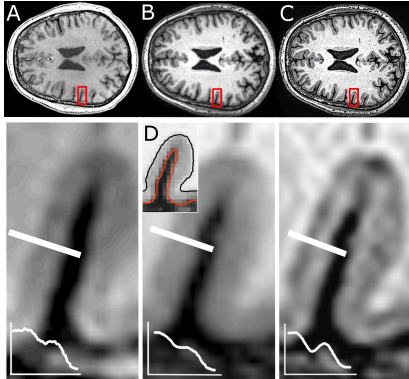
T1-weighted image acquired at 7T (A). T1-weighted image of same subject acquired at 3T (B). Image B after 3D deconvolution (C). White bars denote cross-sections and corresponding profiles shown in lower row. Automatic cortical delineation computed on original 3T (B) image shown in D.
